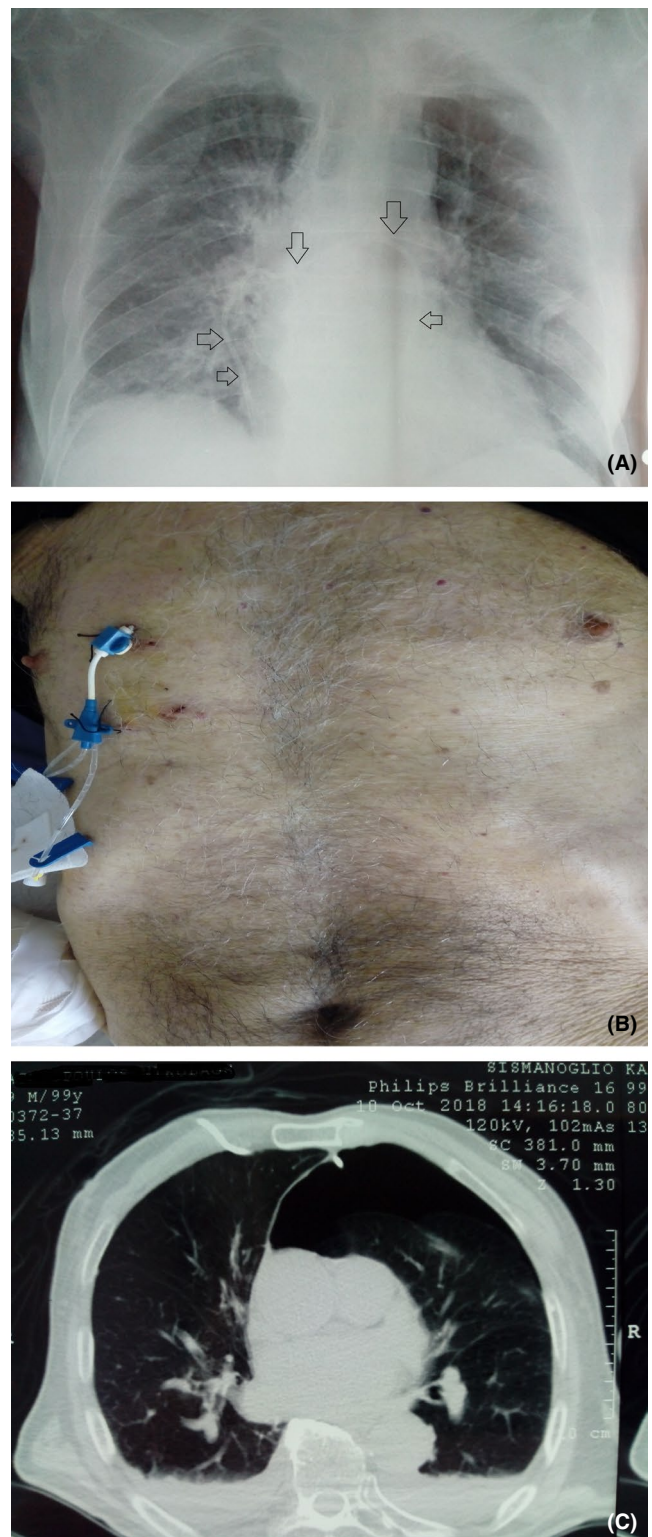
Three-lumen catheter in the right third intercostal space in anterior midclavicular line (A). Chest X-ray: three-lumen catheter in the mediastinal cyst (B) (black arrow). Chest computed tomography: the cyst in the anterior and middle mediastinum was shrinkaged (C)
